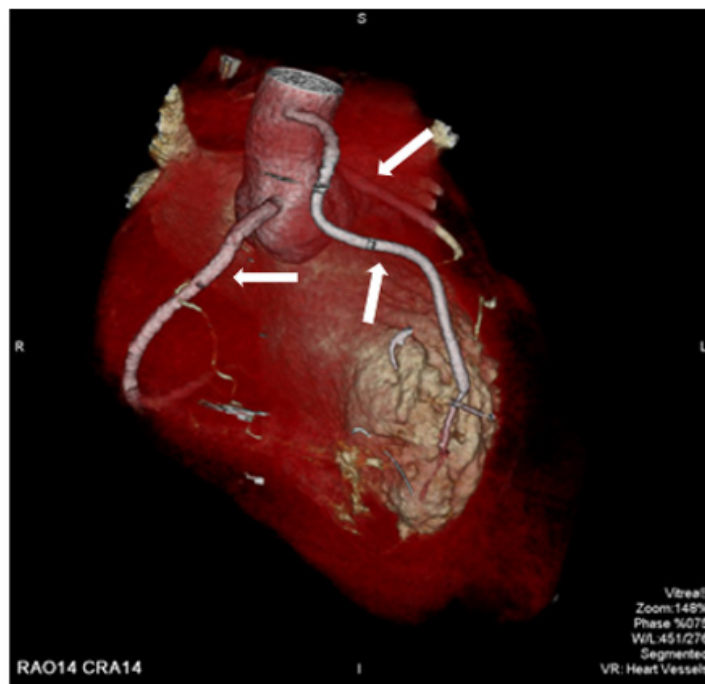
3D CT after venous autograft anastomosis. Arrows show: RCA, venous autograft anastomosis, LAD artery (from the left to the right).
